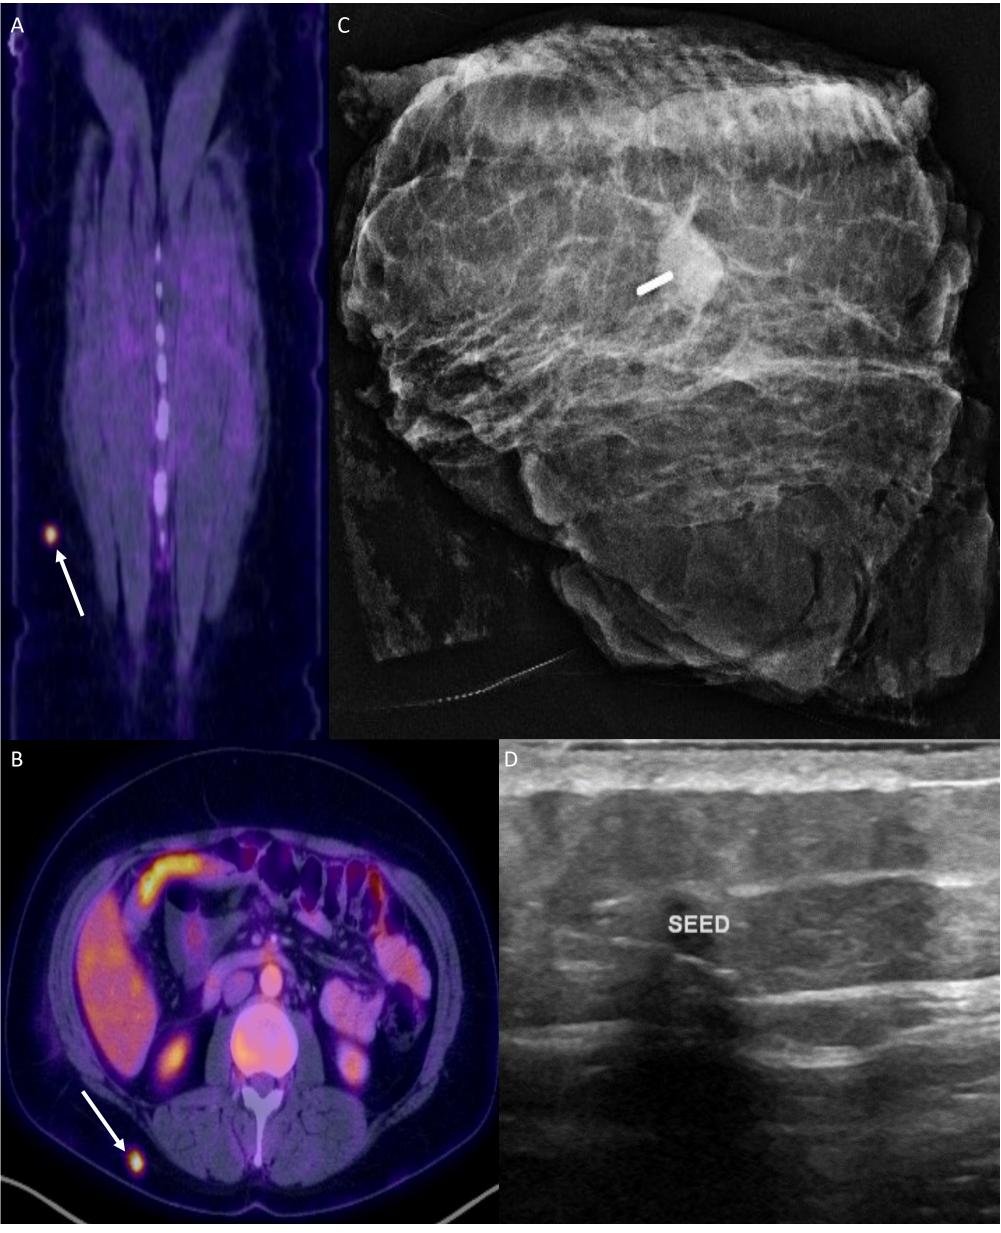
PET/CT demonstrating hypermetabolic mass in right lower back (A and B). Ultrasound-guided radioactive seed placement (C). Post operative mammography of resected tissue with radioactive seed (D).
